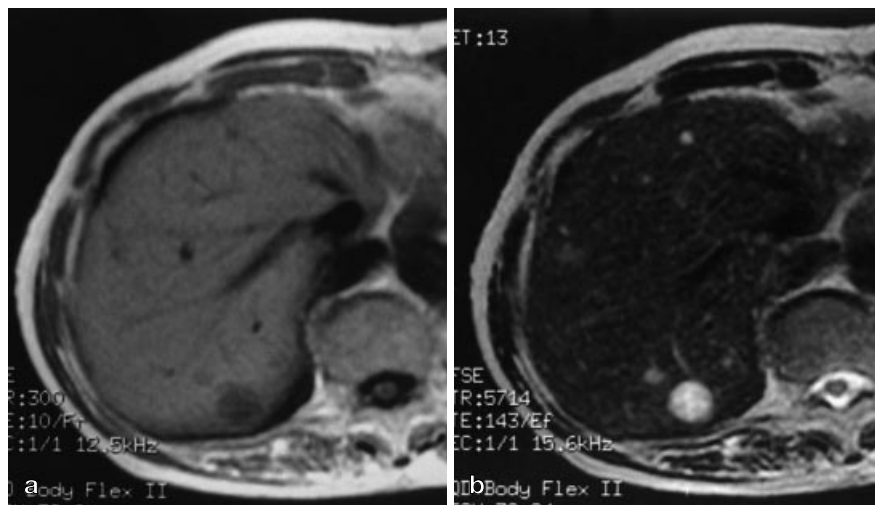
Lymphoma. a On the T1-weighted image, the tumor appears as a large, homogeneously hypointense mass. b The lesion is hyperintense on the T2-weighted image. c In the delayed, contrast-enhanced image, the tumor remains hypointense to liver
